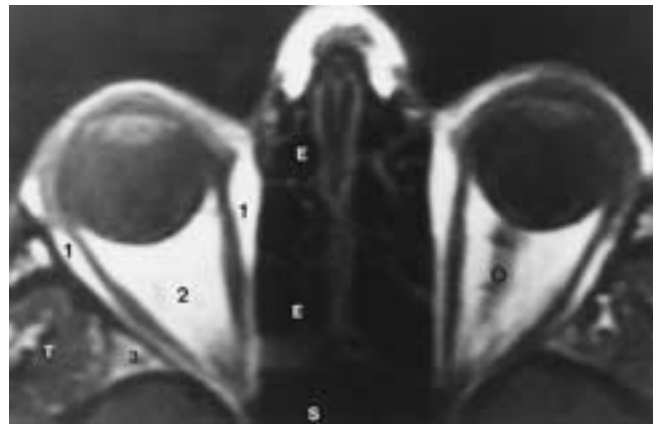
Normal MR imaging anatomy. T1-weighted MR image obtained 3 mm superior to the view in Figure 9-16 shows the optic nerve (0); extraconal fat (1); intraconal fat (2); bone marrow of the greater wing of the sphenoid (3); temporalis muscle (T); ethmoid (E); and sphenoid (S) sinuses.
